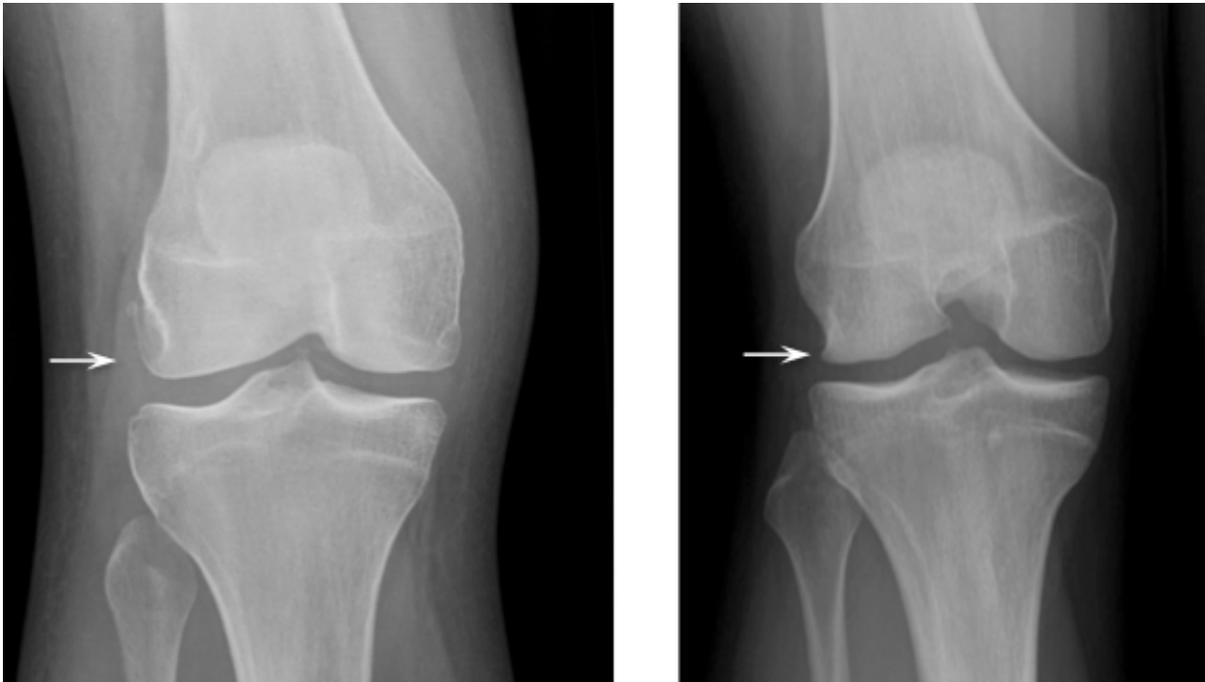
Pseudo-osteophyte lateral femur. Two different normal knees showing a prominent edge (arrows) to the groove for the popliteus tendon in the lateral femoral condyle that can sometimes mimic an osteophyte, thus lowering the specificity of radiographic diagnosis in this location.
